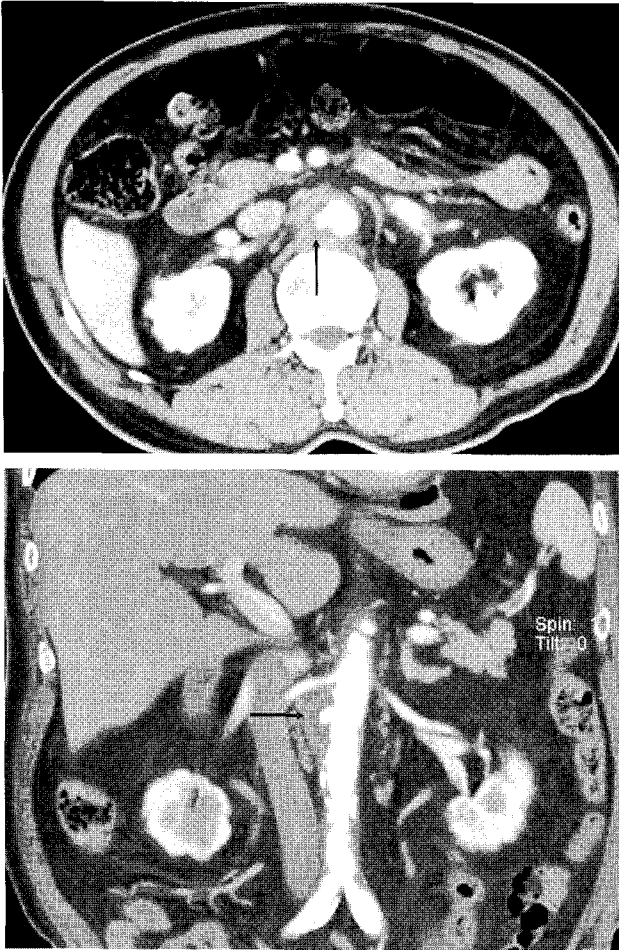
Contrast-enhanced axial and coronal CT images at the level of infra-renal aorta demonstrate saccular aneurysm (arrow) of the aorta, particularly of its right posterolateral lumen, with associated periaortic infiltration.
